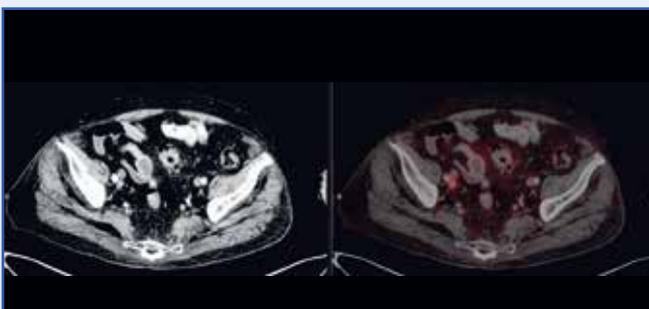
Ga-68 PSMA PET-CT distinctly displays mild to moderate PSMA uptake in the right iliac node.
